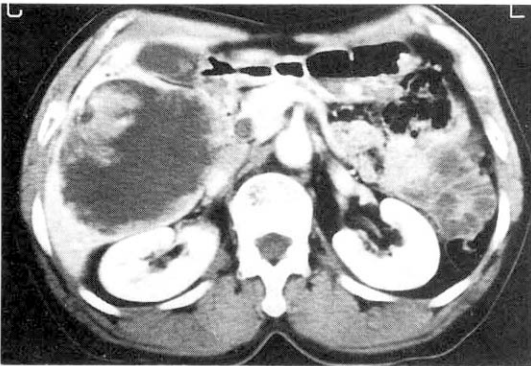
Abdominal CT demonstrates a large cystic lesion within abundant papillary projections in the liver.
